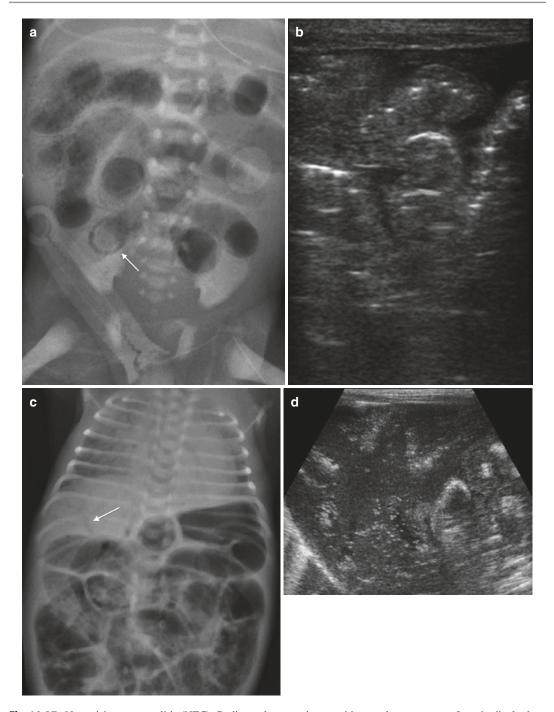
Necrotising enterocolitis (NEC). Radiograph (a) in a neonate with NEC demonstrates bubbly and circumferential lucencies (*arrow*) related to the bowel wall consistent with extensive pneumotosis. US images (b) demonstrates circumferential hyperechoic foci in dependant and non-dependant positions within the bowel wall consistent with intramural air. Supine radiograph (c) in this premature neonate shows generalised asymmetrical bowel loop dilatation. Branching lucencies are seen in the right upper quadrant (*arrow*) extending to the periphery
